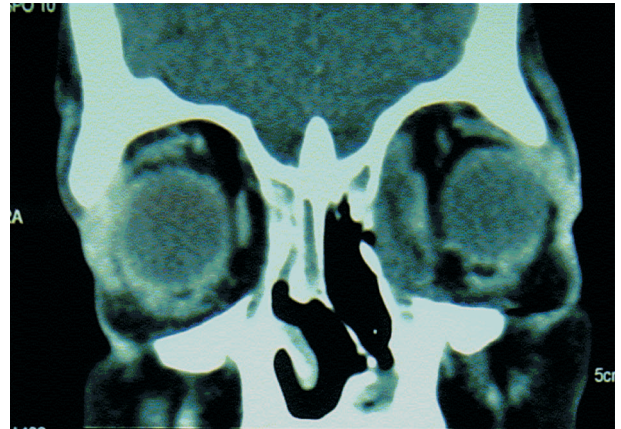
Computed tomography coronal scan of orbits and ethmoid sinuses showing total opacification of the sinuses with a localized hypodense lesion in the left orbit.
